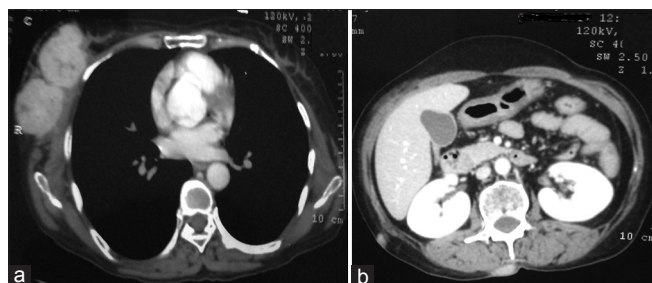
(a and b) Contrast-enhanced computed tomography scan of the thorax and abdomen after three cycles of chemotherapy showed stable disease
